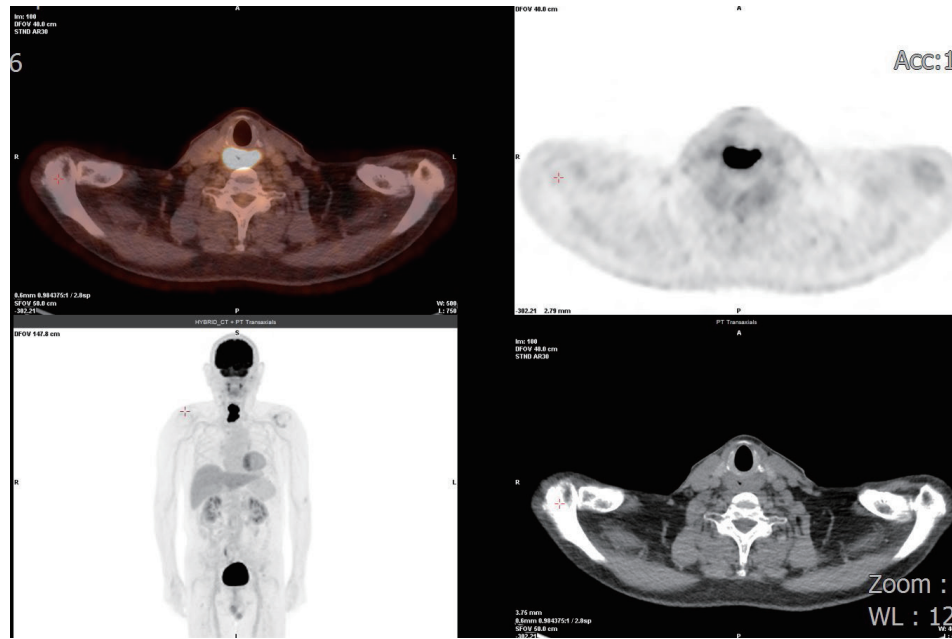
圖二 在正子電腦斷層造影掃描中，影像顯示 ¹⁸F-FDG 葡萄糖異常活度吸收涉及環狀軟骨後區域。
